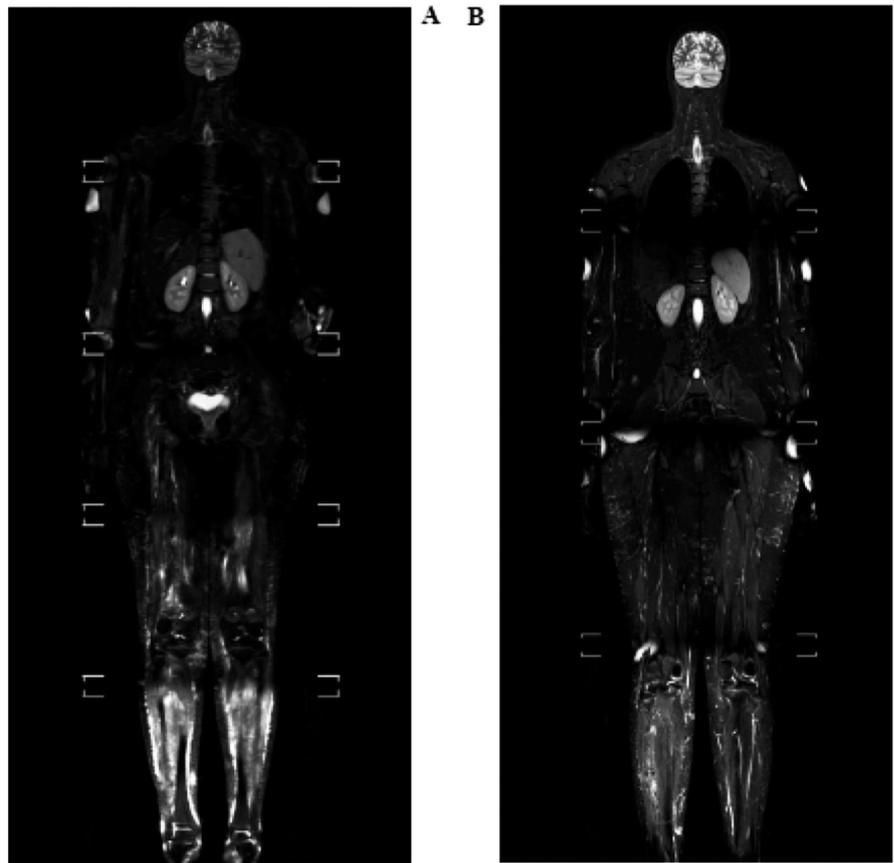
Whole body magnetic resonance imaging before (A) and six months after (B) starting baricitinib treatment.
